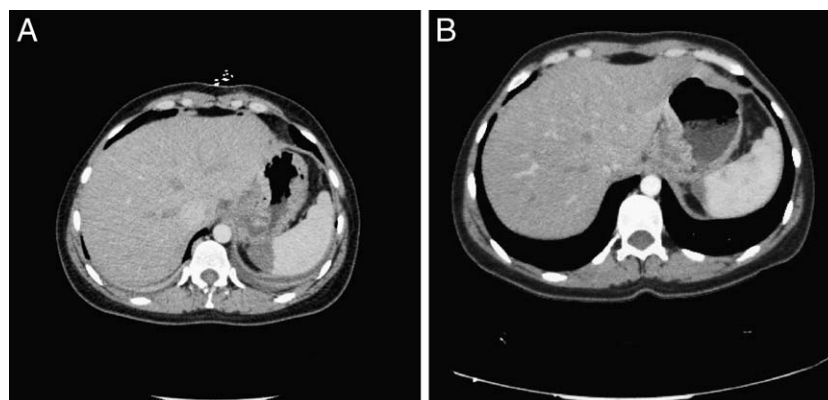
(A) CT scan demonstrating an area of splenic infarction of the upper pole. (B) A repeat CT scan at 6 weeks demonstrating nearly complete resolution and atrophy.
